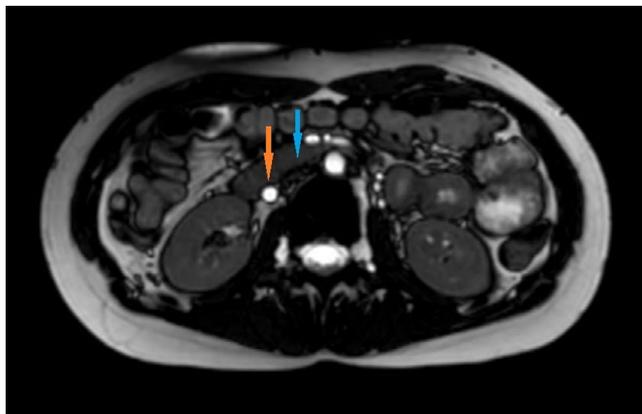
Axial balanced fast field echo (BFFE) MRI images at L2/L3 level above the iliac bifurcation. Blue arrow points to the atretic vena cava inferior with no flow. Orange arrow points to the dilated right ovarian vein, left ovarian vein is also prominent because of the collateral venous flow
